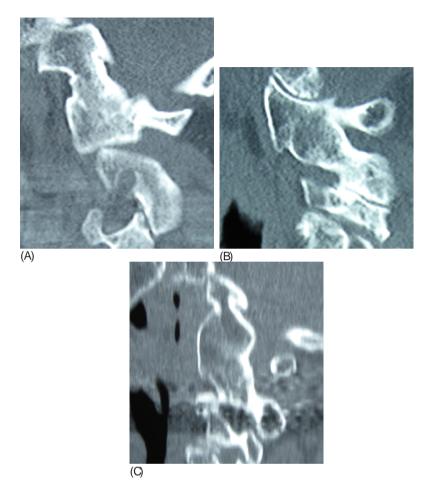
Ankylosis of the upper-cervical spine facet joint on CT A: O/C1 type, B: C1/2 type, C: O/C2 type
